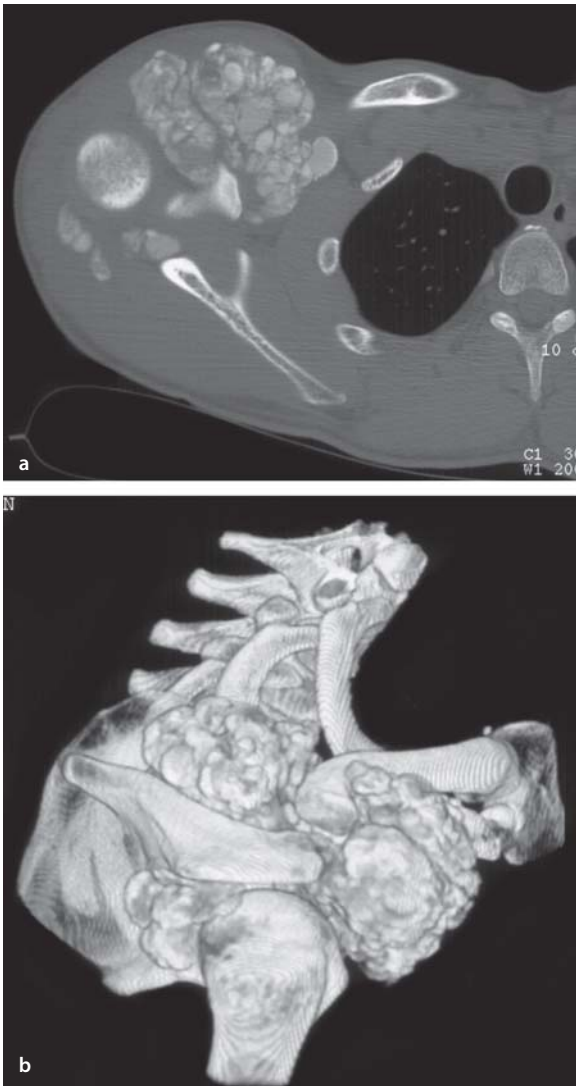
a,b. Tumoral calcinosis associated with chronic renal failure. a Computed tomography. b Surface-rendered 3D reconstruction. Soft tissue masses with amorphous calcification. The distribution is readily appreciated on the reconstruction (b)
